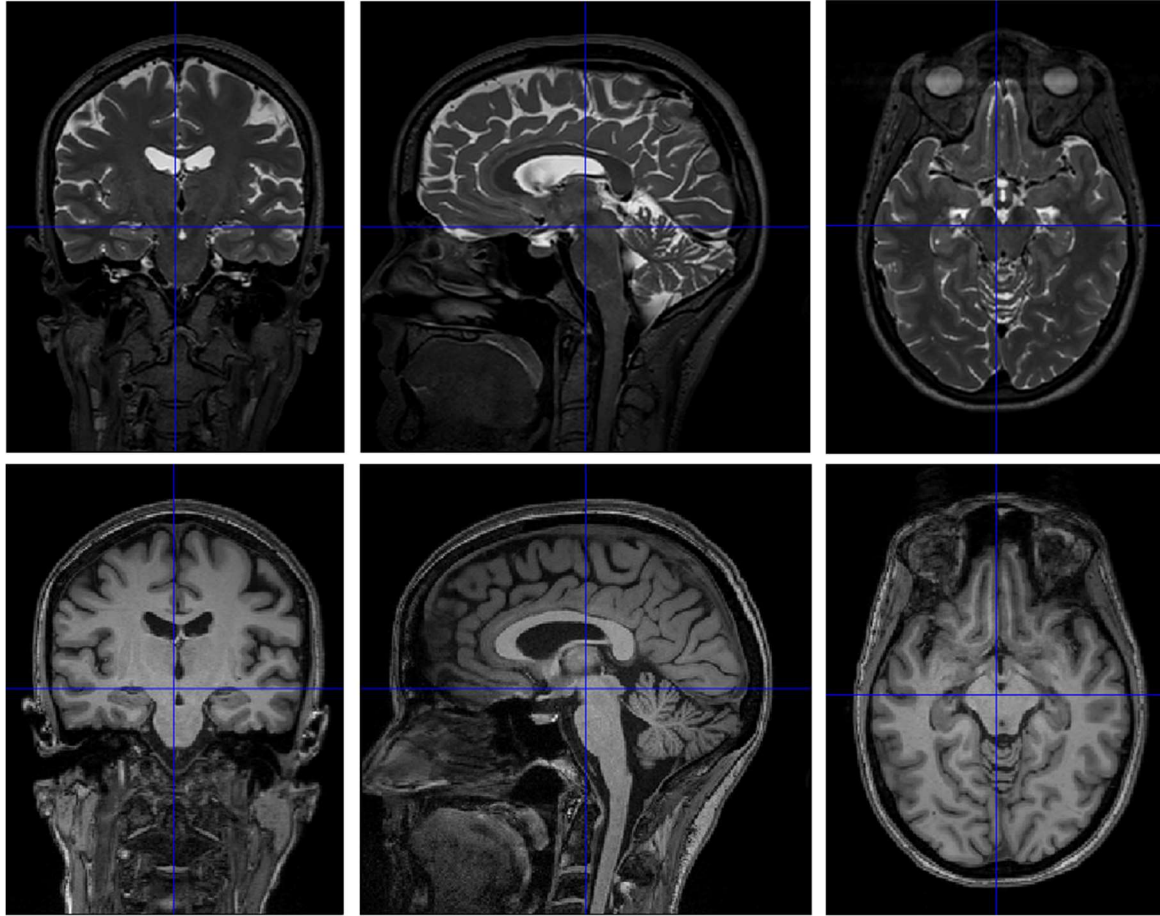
Comparison of T2-weighted MRI (top) with T1-weighted MRI (bottom) showing contrasting images between WM and GM. Obtained using a 3T MRI scanner (Lewis Center for Neuroimaging, University of Oregon).
